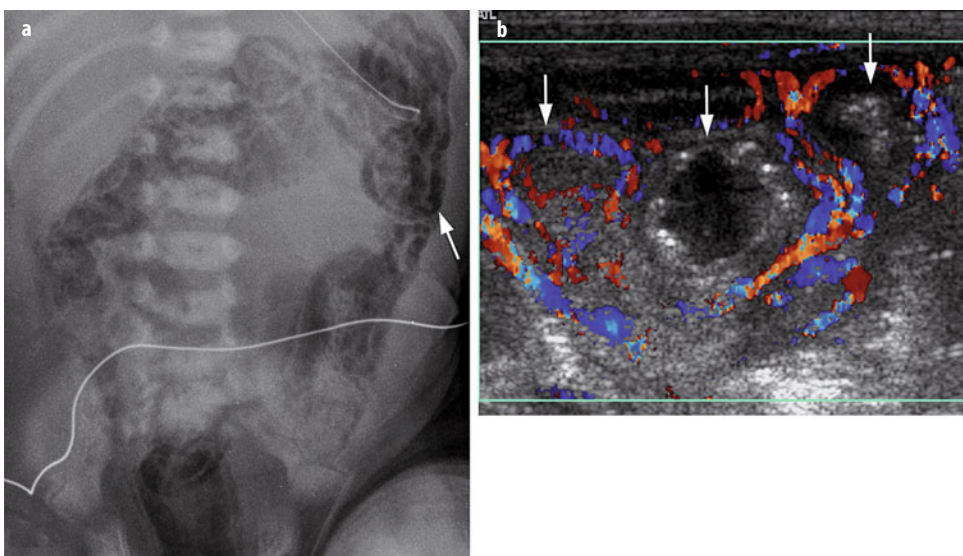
a, b. a Plain radiograph in a 7-day-old neonate with necrotizing enterocolitis (NEC) shows a marked amount of intramural gas throughout the distribution of the large bowel and rectum. Intramural gas is very easily seen in the region of the descending colon (*arrow*). b Color-Doppler ultrasound (US) image in a 10-day-old neonate with NEC shows three loops of bowel (*arrows*). The two outer loops are well perfused and indeed are hyperemic, indicating viability. The central loop is distended with fluid and has some hyperechoic foci in the wall, consistent with intramural gas; this loop has no flow and was proven to be necrotic at surgery
